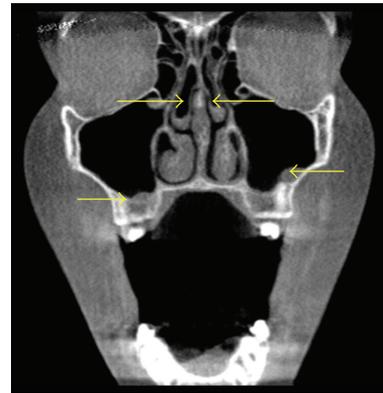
Coronal CT scans demonstrating bilateral middle concha bullosa (superior arrows) with bilateral maxillary sinusitis (inferior arrows). Note that there is more mucosal thickening on the left floor of the maxillary sinus than the right sinus floor, whereas the right concha bullosa demonstrates a greater degree of pneumatization compared to the left concha bullosa.
